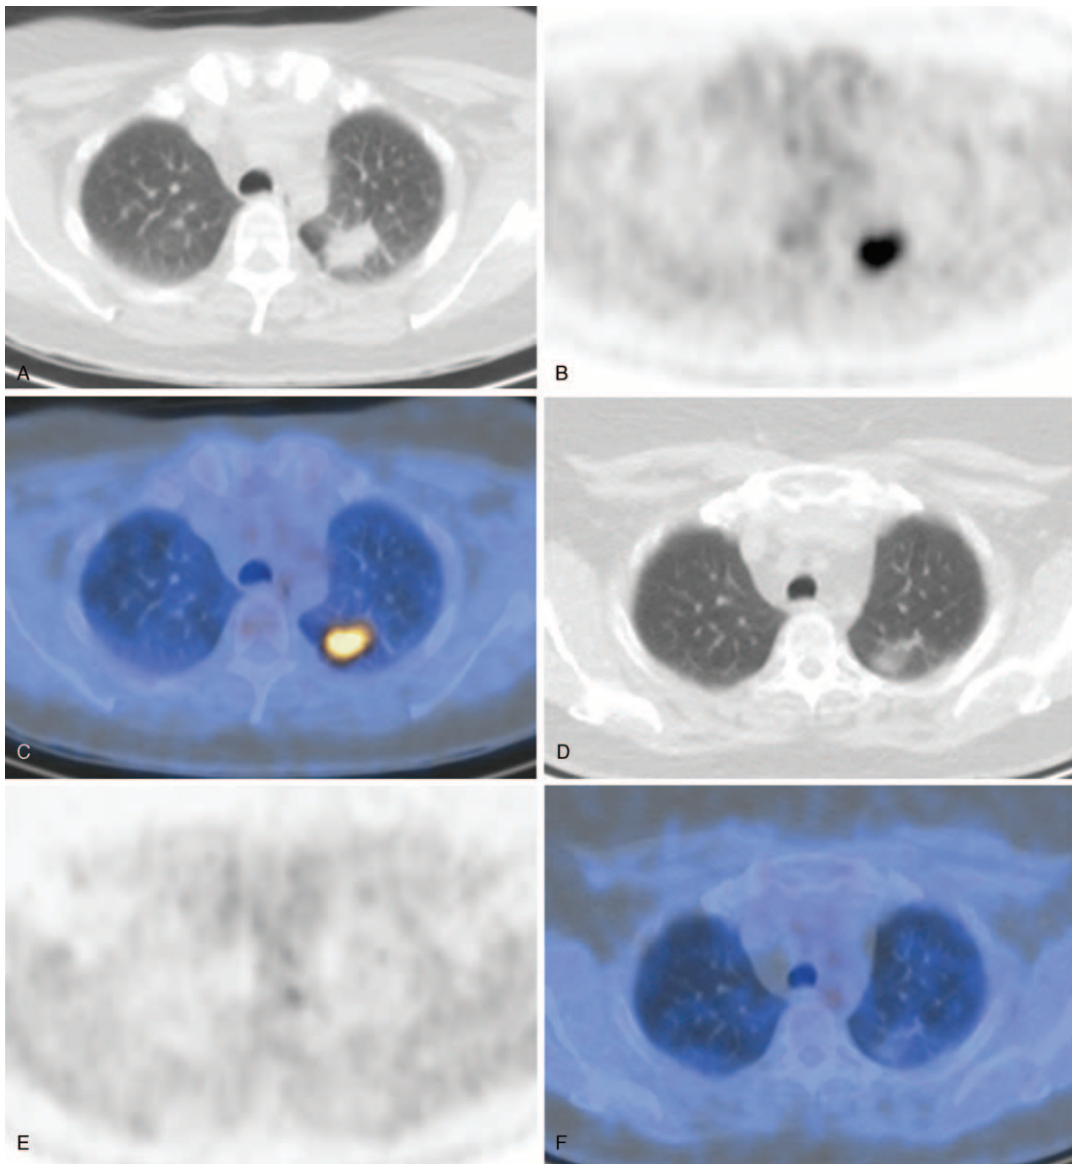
Examples of fusion PET/CT images of AAV patients during follow-up. (A) CT scan, (B) PET scan, and (C) fusion PET/CT of a patient with suspected pulmonary disease activity. (d) CT scan, (E) PET scan, and (F) fusion PET/CT of the same patient 5 months later after intensified immunosuppressive treatment. AAV = anti-neutrophil cytoplasmic antibodies-associated vasculitis, CT = computed tomography, PET = positron emission tomography.
